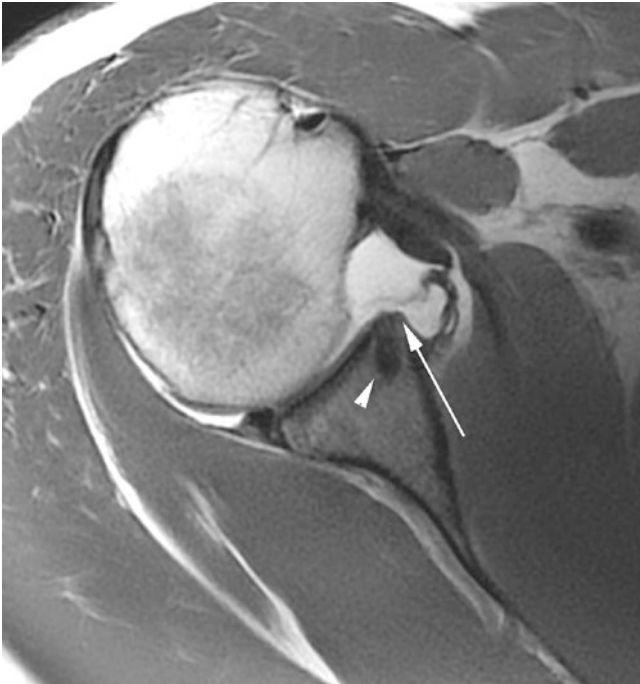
Axial T1-weighted image from direct MR arthrogram demonstrates a failed Bankart repair with a missing antero-inferior labrum (arrow) and lack of the “bumper” along the glenoid rim. Note artifact from prior repair (arrowhead)
